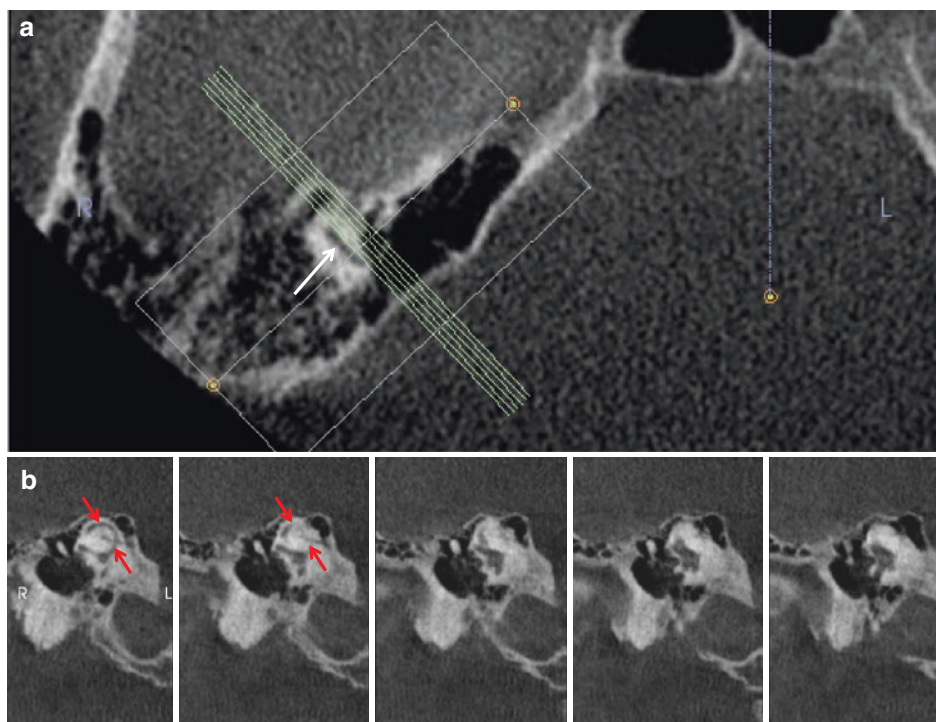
Cropped CBCT axial image (a) shows the location and orientation (green lines) of the Stenvers slices reconstructed in a direction perpendicular to the course of the superior (anterior) semicircular canal (red
